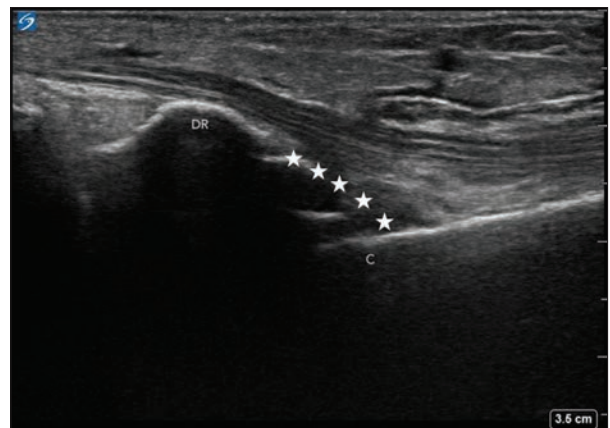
Sonographic anatomy of distal radius fracture (longitudinal view). DR: Distal radius, C: Proximal cortex, ★: Fracture haematoma.
